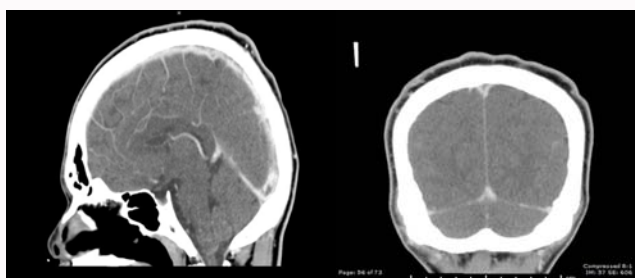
Sagittal and coronal CT venography images showing substantial resolution of the thrombosis leaving minimal residual at the superior aspect of the posterior sagittal sinus.
